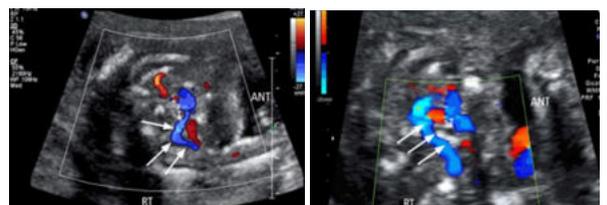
Doppler examination showing aberrant right subclavian in front of trachea (Normal) and behind the trachea which is abnormal.
